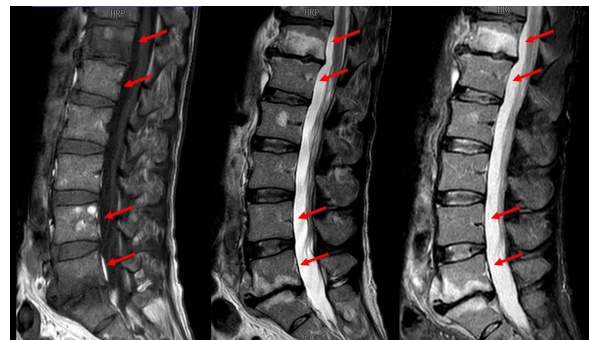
MRI showing spondylodiscitis signs on D12-L1 and L4-L5 like reduction of intervertebral space and irregularities and edema of the vertebral platforms.
